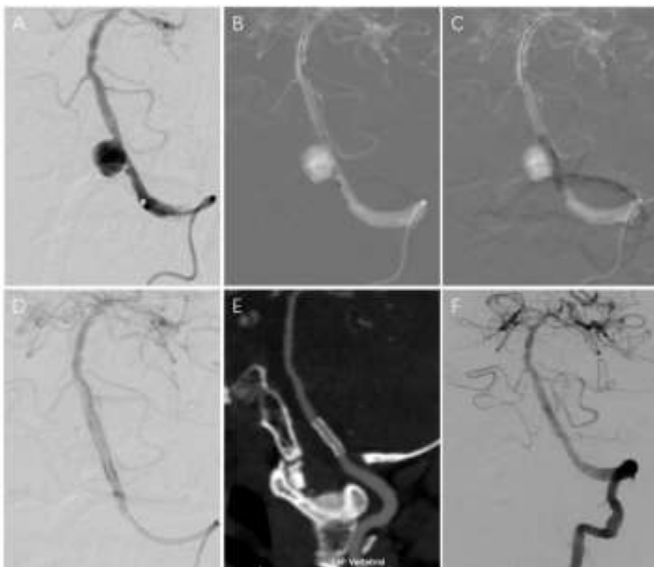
A 65-year-old male suffered from SAH. A, a dominant left VA angiogram revealed a spherical dissecting aneurysm on the V4 segment proximal to PICA and the stenosis on the proximal to the aneurysm; B and C, under the roadmap, Willis covered stent ($3.5 \times 16\text{mm}$) was implanted; D, immediate angiograms post EVT demonstrated the complete occlusion of the VADA; E, CTA of the 1 month follow-up demonstrated the stable occlusion of the VADA and patency of VA without any stenosis; F, the 6 months follow-up angiograms demonstrated the complete occlusion of the VADA and reconstruction of the diseased VA with no in-stent stenosis.
